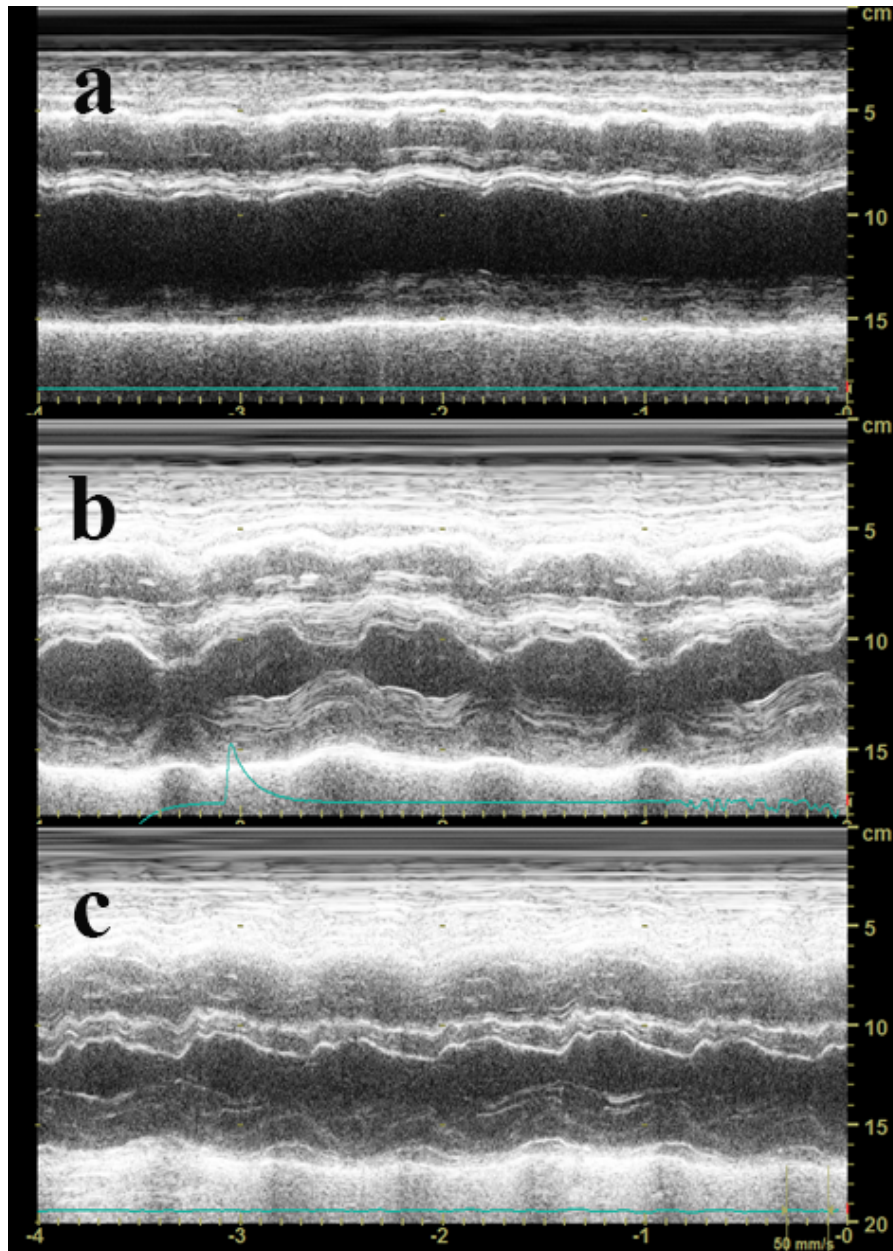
The echocardiographic left ventricular M-mode images of the first day, the 10<sup>th</sup> day and the 17<sup>th</sup> day after admission. a: left ventricular diameter was enlarged and ejection fraction was decreased on first day of admission; b: this figure shows edema of left ventricular wall and improvement of LVEF. c: the last examination of bedside echocardiography shows normal LVEF and wall thickness.
